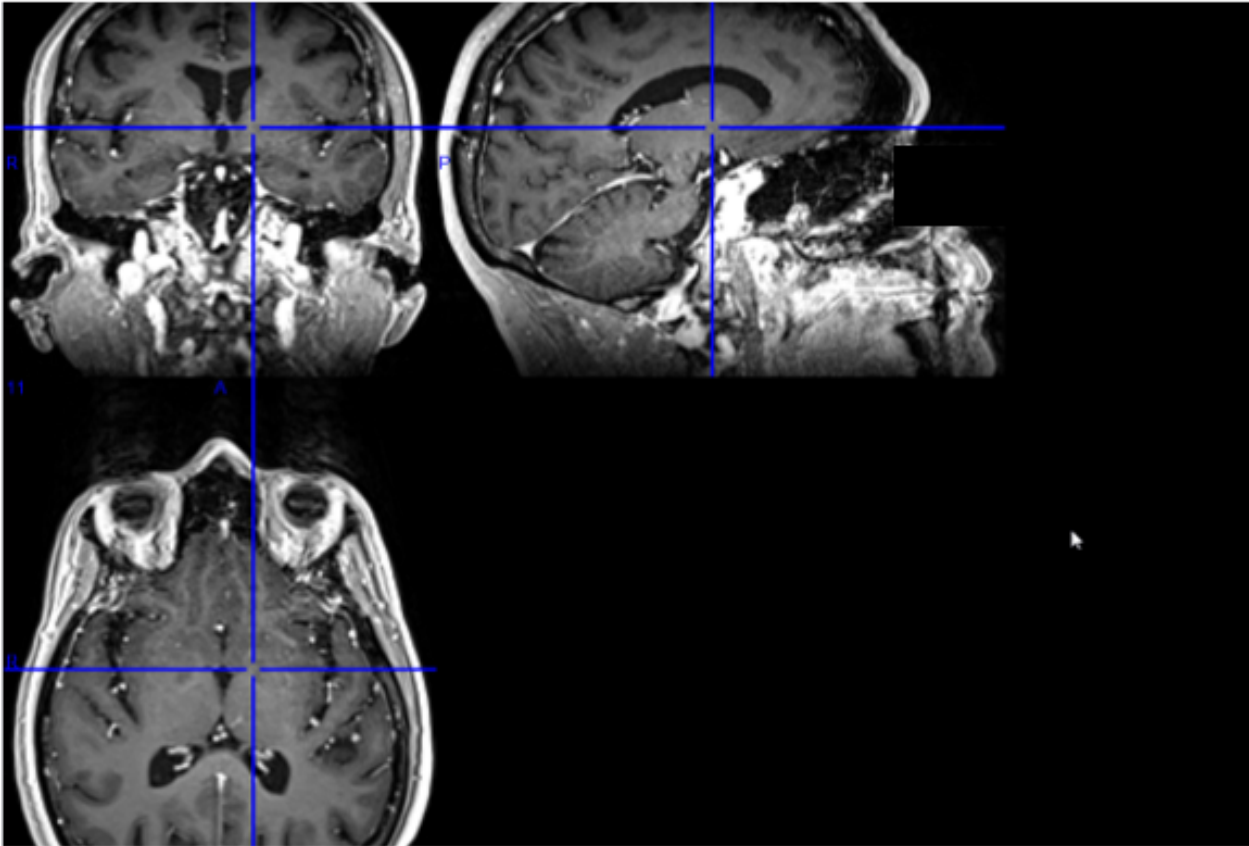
Pre-operative MRI
